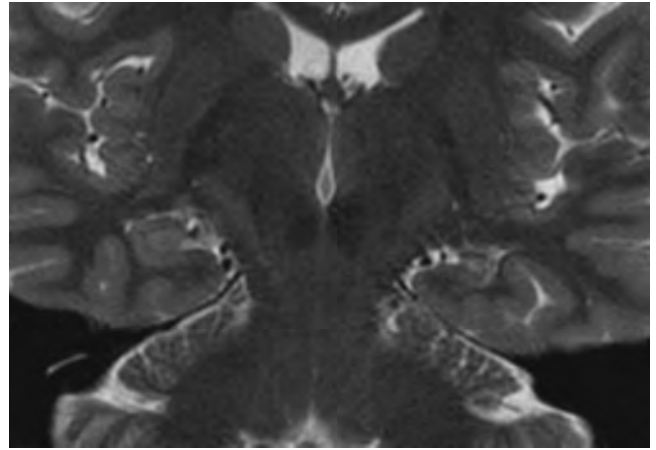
Left hippocampal sclerosis. Coronal T2-weighted image showing atrophy and increased T2 signal in the left hippocampus. The right hippocampus is normal.
